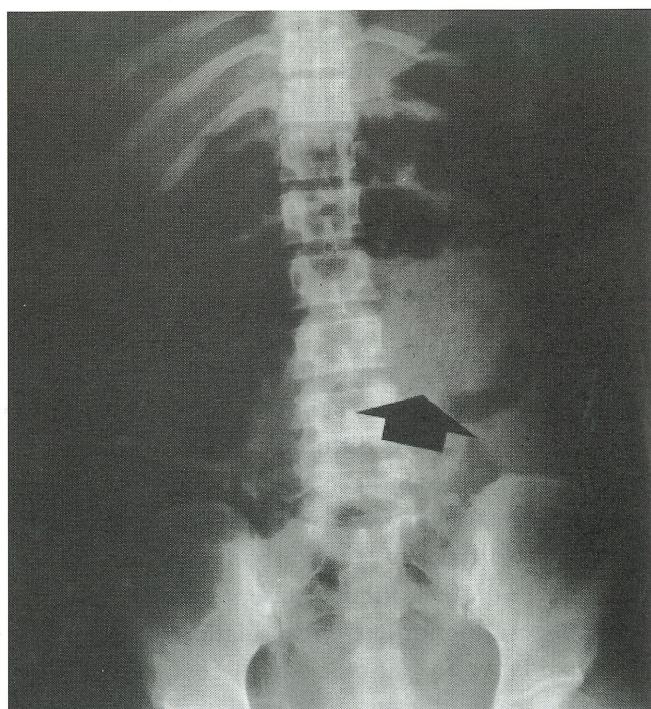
Plain abdominal radiograph showed whorl-like shadow in mid-part abdomen. (arrow)
